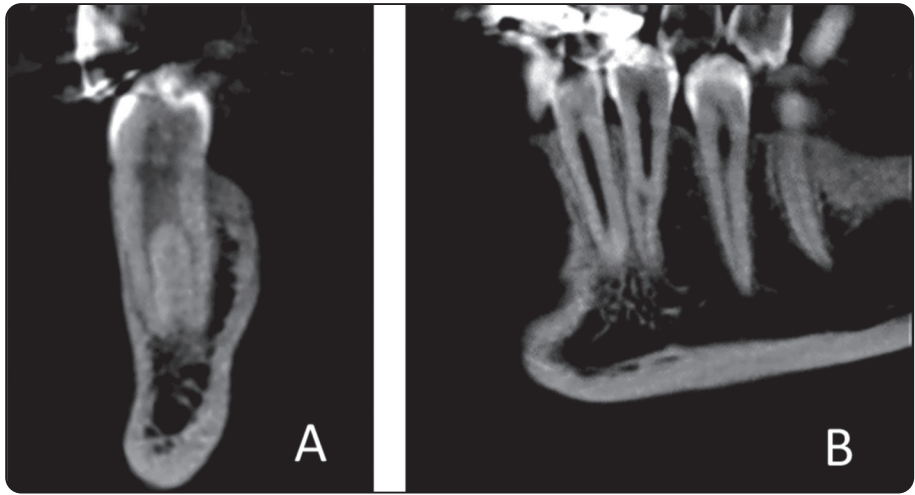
CBCT images of 2 rooted mandibular right first premolar. A Coronal view showing buccal and lingual roots . B Sagittal view showing fading of the root canal in middle third ( fast break).
